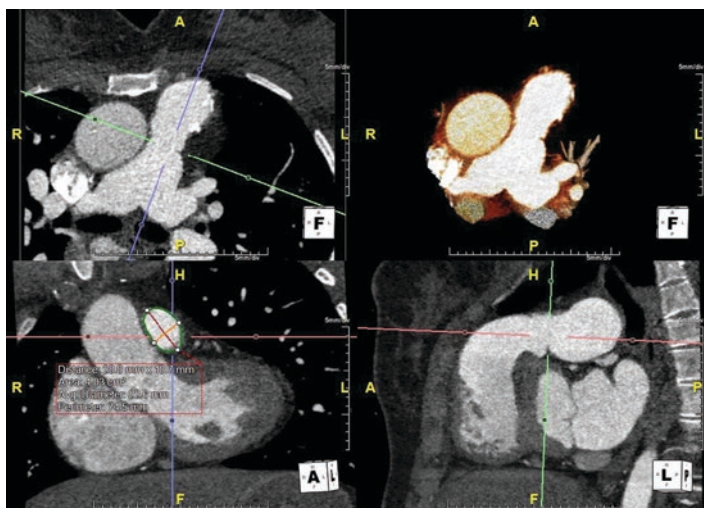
Cardiac CT angiography of an adult patient with tetralogy of Fallot demonstrating assessments and measures of the RV outflow tract
